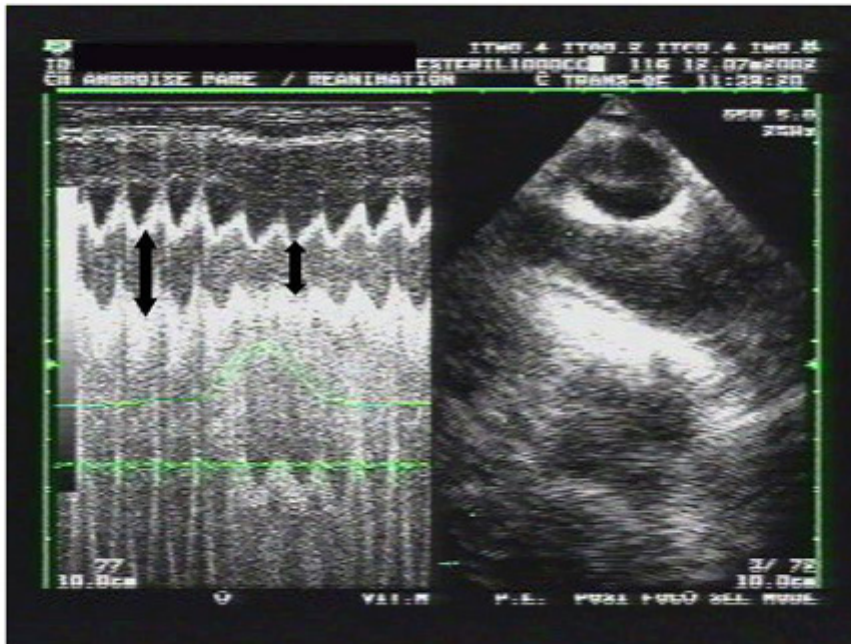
Measurement of the collapsibility index of the SVC from a longitudinal view (see figure 2), recorded using two-dimensional and M-mode echocardiography. The maximum diameter (D_{max}) is observed on expiration, while the minimum diameter (D_{min}) is observed at the inspiration plateau.
